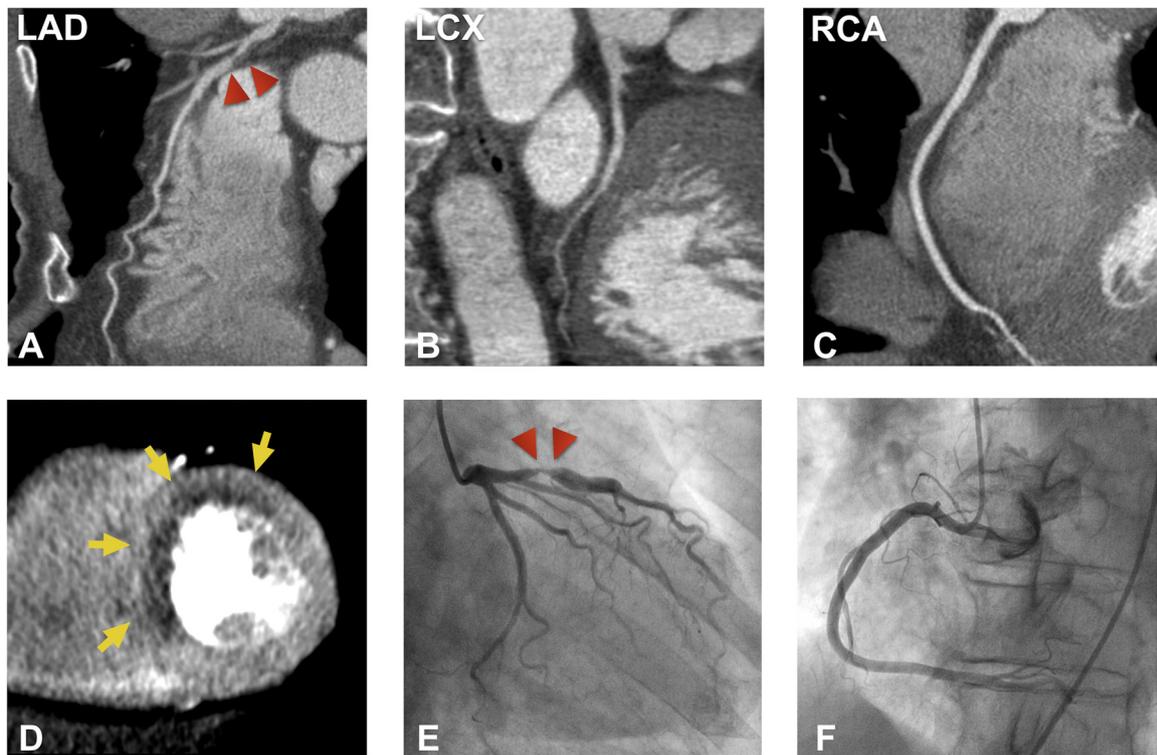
A 63-year-old man with stable angina. Coronary computed tomography angiography showed severe stenosis in the proximal portion of the left anterior descending artery (LAD) (red arrowhead) (A), and no significant stenosis in the left circumflex artery (LCX) or right coronary artery (RCA) (B and C). Computed tomography perfusion imaging showed a subendocardial perfusion defect in the antero-septal left ventricle wall (yellow arrow) (D). A quantitative computed tomography perfusion assessment revealed that the mean computed tomography-derived myocardial blood flow (CT-MBF) in the LAD, LCX, and RCA territories were 0.85 mL/g/min, 1.67 mL/g/min, and 1.36 mL/g/min, respectively. The CT-MBF in the LAD territory was lower than the cut-off value (1.26 mL/g/min), and the patient was suspected of having myocardial ischemia. Invasive coronary angiography revealed severe stenosis in the proximal portion of the LAD (red arrowhead) (E), and no significant stenosis in the LCX or RCA.
